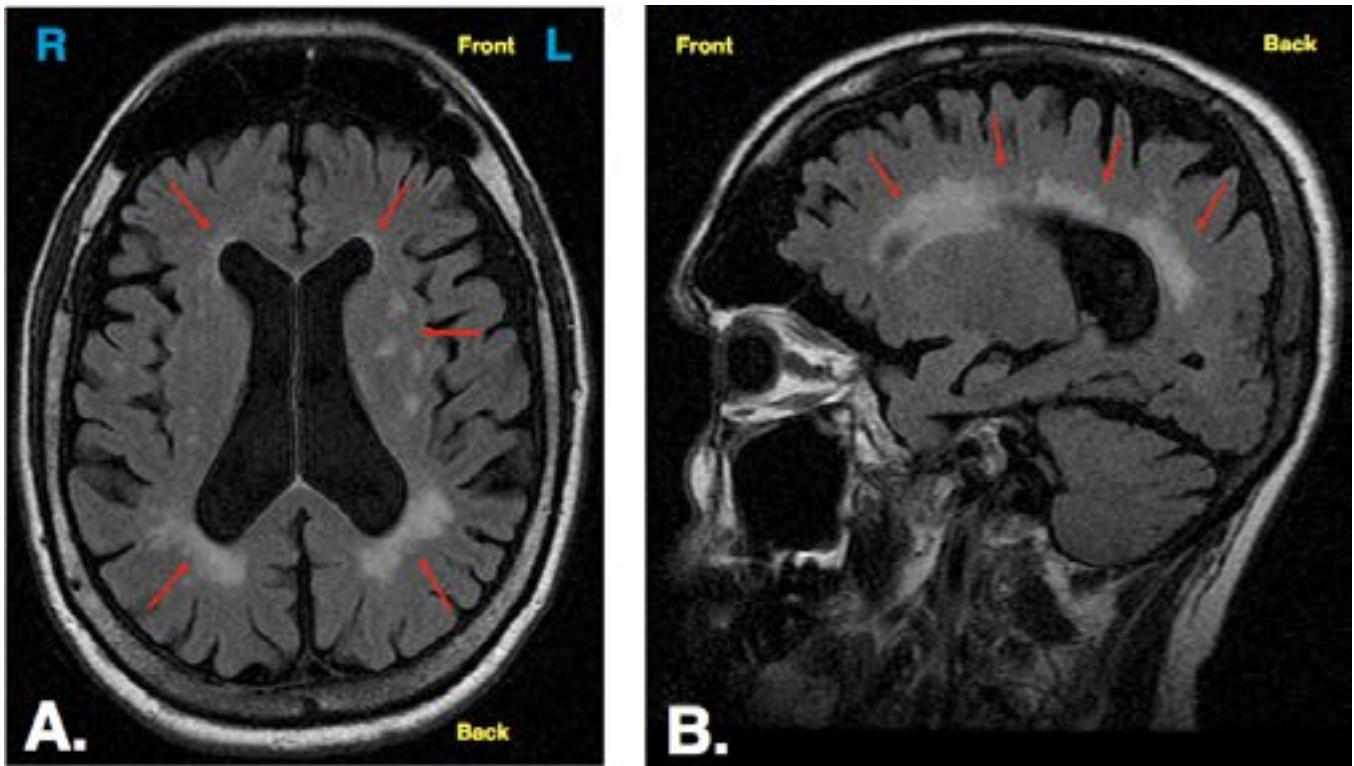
Representative WMH lesions on fluid attenuated inversion recovery (FLAIR) brain MRIs (A = transverse view; B = sagittal view). Notice that most WMH lesions are mainly located in the periventricular white matter of the human brain (red arrows). Initially described in patients with cardiovascular risk factors and symptomatic cerebrovascular disease, WMH are now associated with progressive cognitive impairment in the elderly (Wardlaw, 2015). It appears that the greatest risk factor for developing white matter damage is high blood pressure. We are learning that these WMH are much more widespread than we thought as they are also detected in healthy cohorts as well. R = right; L = left.
